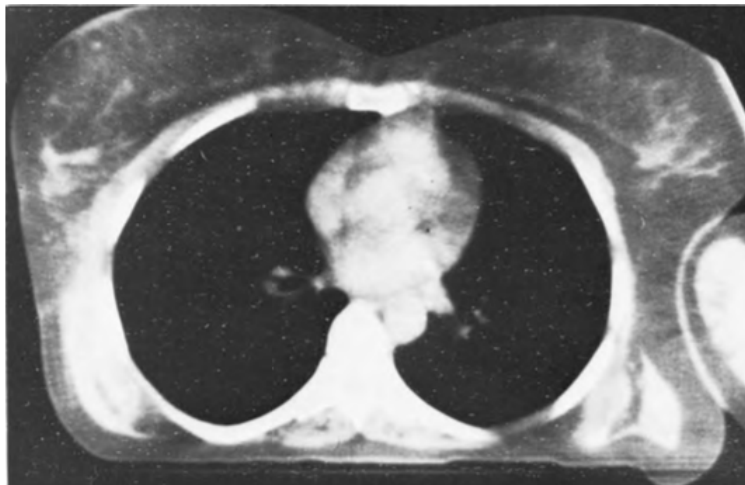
Example of a CT image showing the heart and lungs. Darker areas correspond to low density tissue (such as the lungs) and lighter areas correspond to high density tissues (such as the heart). Taken from [28].
